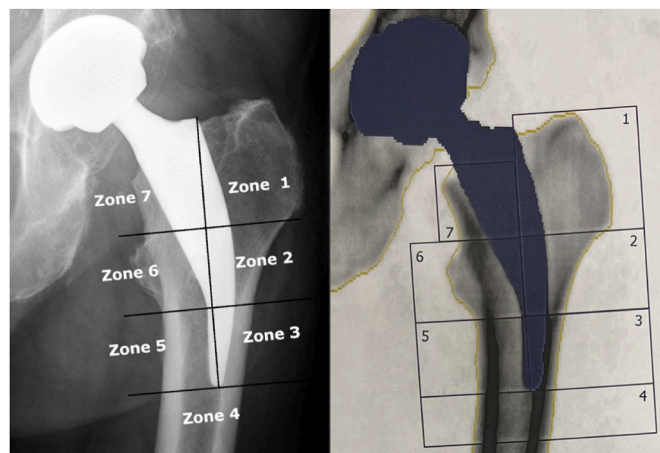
ROIs adapted to cementless short stem prostheses in a radiograph (left) and in an osteodensitometric planning image (right).
